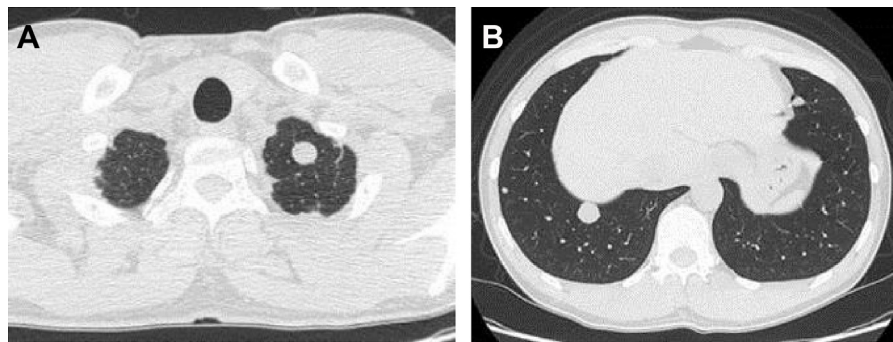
Pre-operative chest computed tomography images showing solid tumors in the left upper lobe (A), right lower lobe, and left lingular segment (B).
